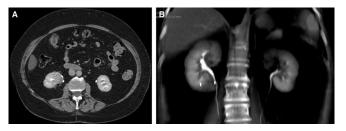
CT-scan 6 months following radio therapy with CyberKnife. (A) Axial and (B) coronal images demonstrate the renal mass between the 2 fiducial markers (arrows).
